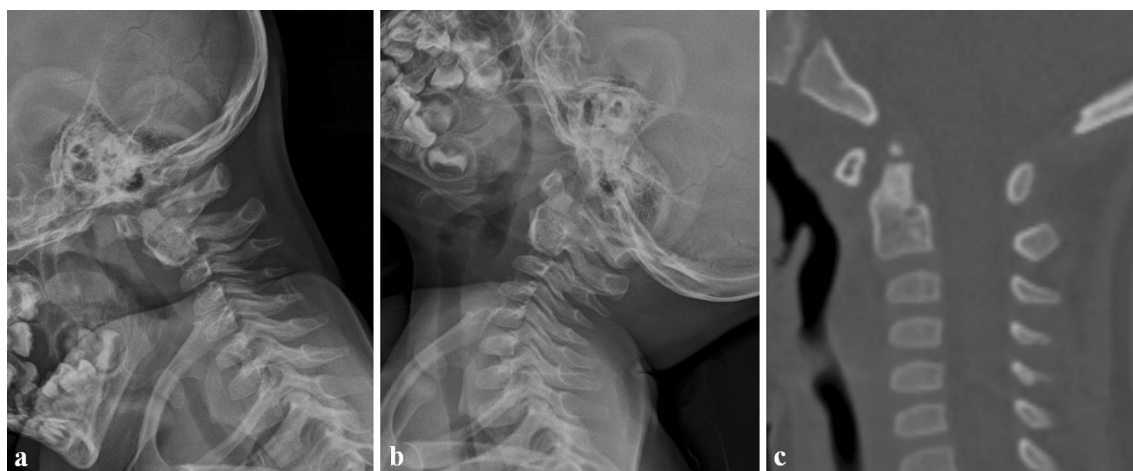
Follow-up analysis 18 months after the surgery revealed a, b no radiologic instability via cervical spine dynamogram and c union of odontoid synchondrosis via computed tomography sagittal
